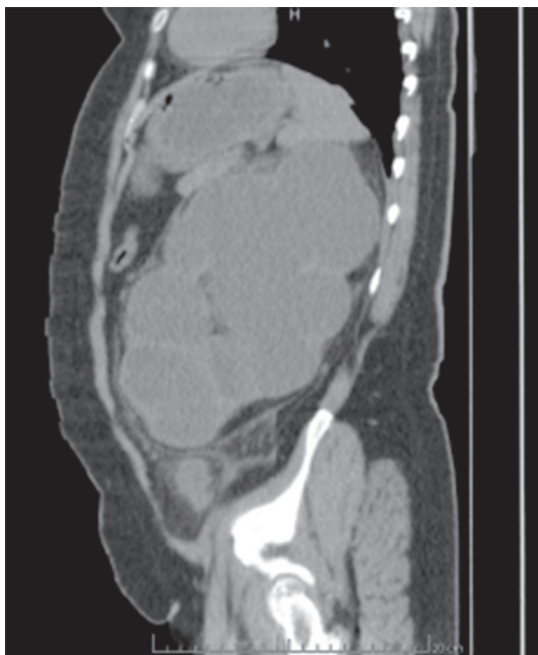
Abdominal computed tomography transverse section. The homogeneously dense mass with smooth lobulated margins is covering left half of the abdomen
